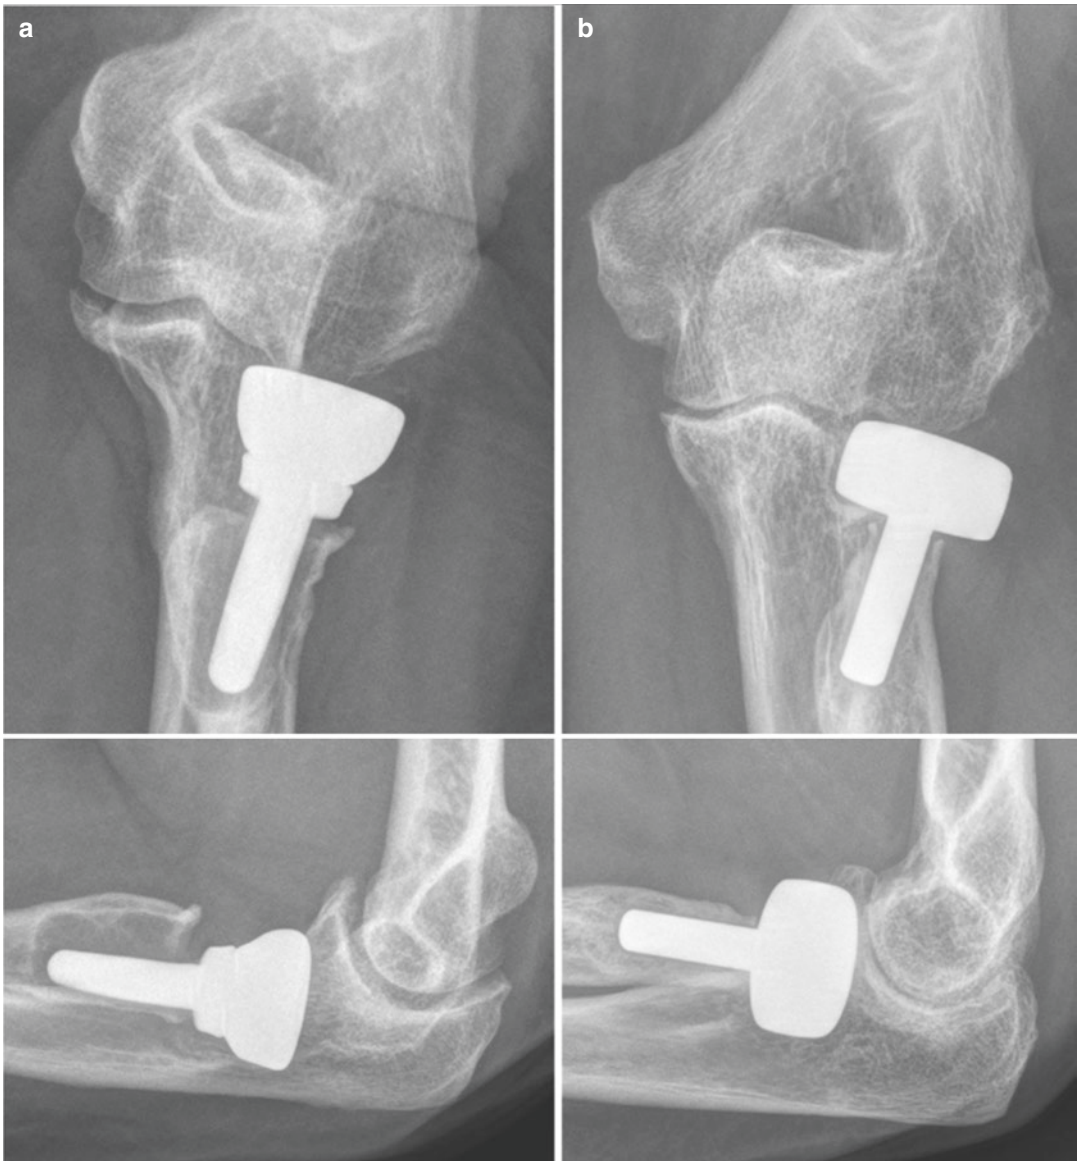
(a) Radiographic control of the Acumed prosthesis at 13 years of follow-up (severe osteolysis in asymptomatic patient), (b) X-ray control of the EVOLVE prosthesis at 15 years of follow-up
